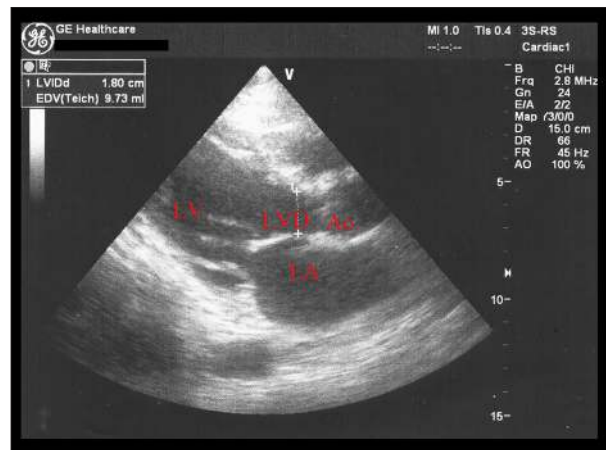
Parasternal long axis window in echocardiogram. Ao – aorta; LA – left atrium; LV – left ventricle; LVD – LVOT diameter.
